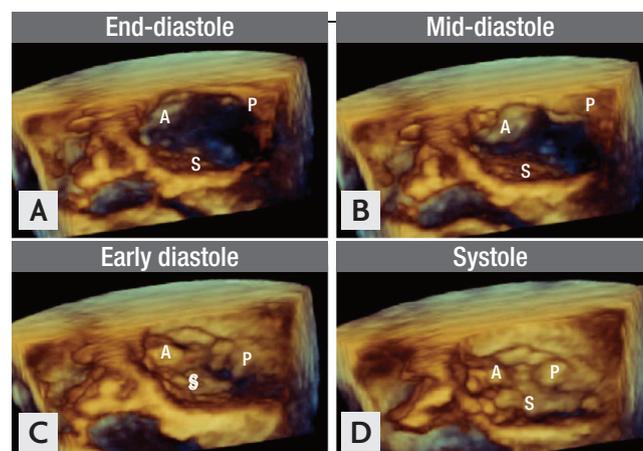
Three-dimensional transesophageal close up views of the normal tricuspid valve in a cardiac cycle. (A) Panel shows the tricuspid valve in end-diastole, (B) in mid-diastole, (C) in early diastole, and (D) in systole. A, anterior cusp; P, posterior cusp; S, septal cusp.
